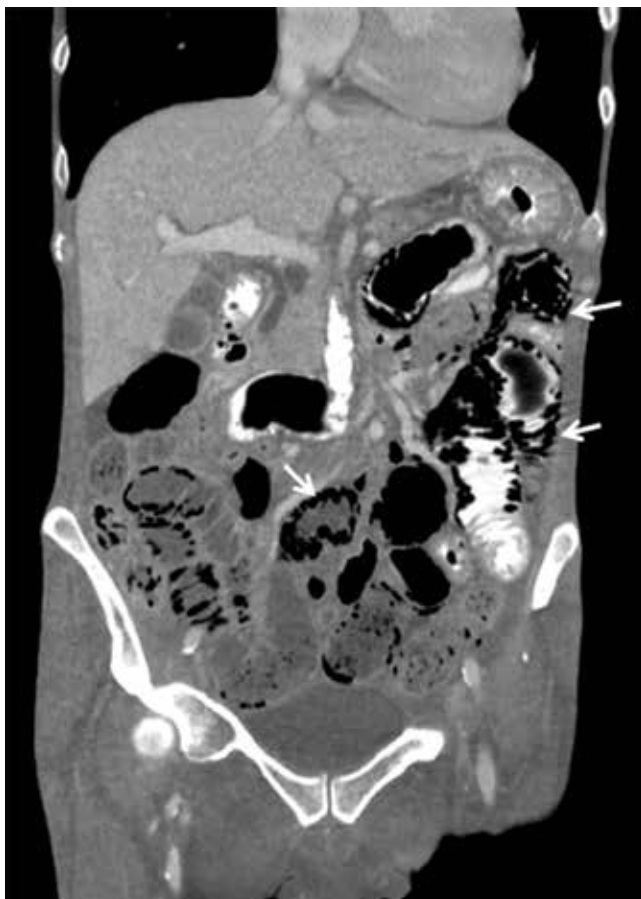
On abdominal computed tomography, the coronal view (left) and the sagittal view (right) showed pockets of intramural gas within the small intestine (arrows).
